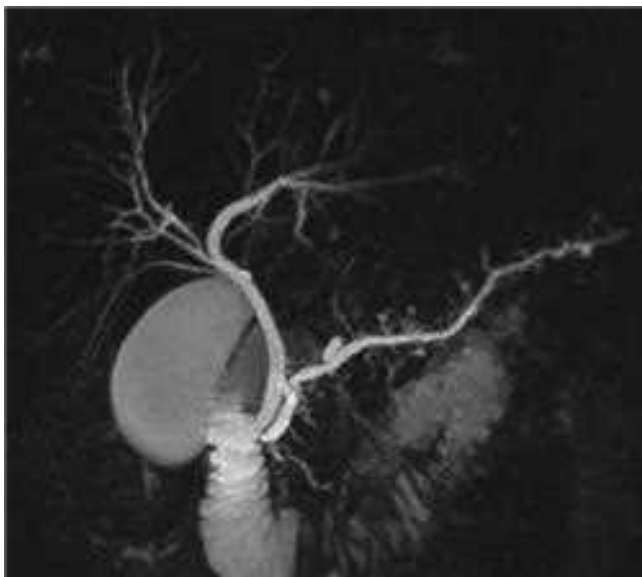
Coronal T2-weighted magnetic resonance image showing evidence of chronic pancreatitis, including a pancreatic duct dilatation and side-branch clubbing. (Reproduced with permission of Mellena Bridges, MD, Mayo Clinic Jacksonville, Department of Radiology.)
